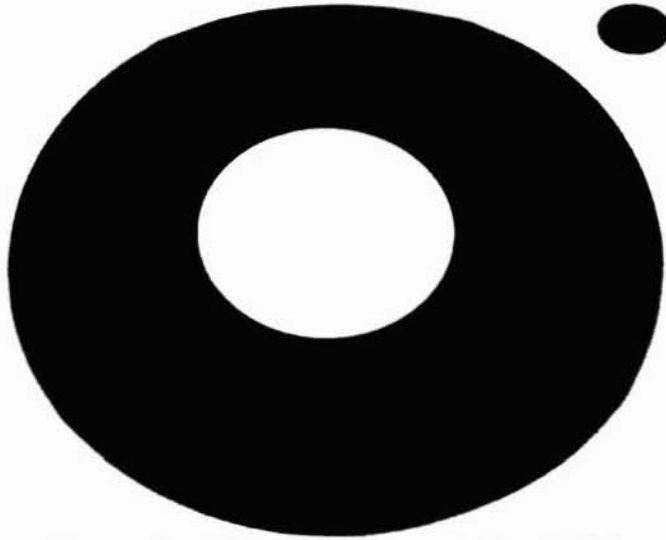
X-ray photographs of NR vulcanizates containing 100 phr precipitated zinc oxide prepared from zinc acetate (NR-ZnO/A)
